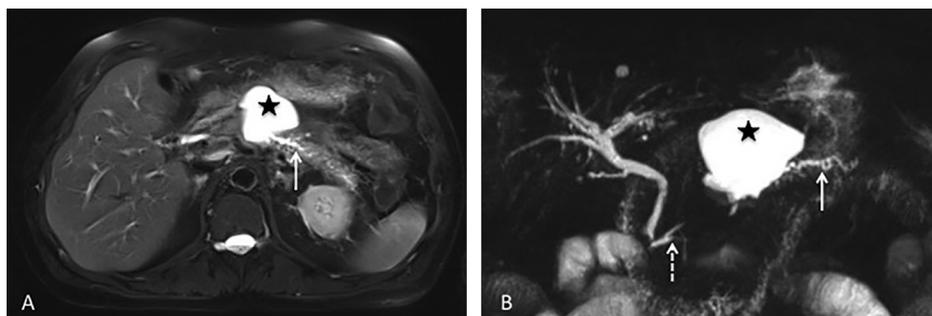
Disconnected pancreatic duct syndrome: Magnetic Resonance Imagery. Cross-sectional (Figure 4A) and frontal (Figure 4B) slices. The star shows the collection of pancreatic fluid situated face to the neck, the shaded arrow the major pancreatic duct downstream, discretely dilated, and the dotted arrow the main cephalic pancreatic duct.
